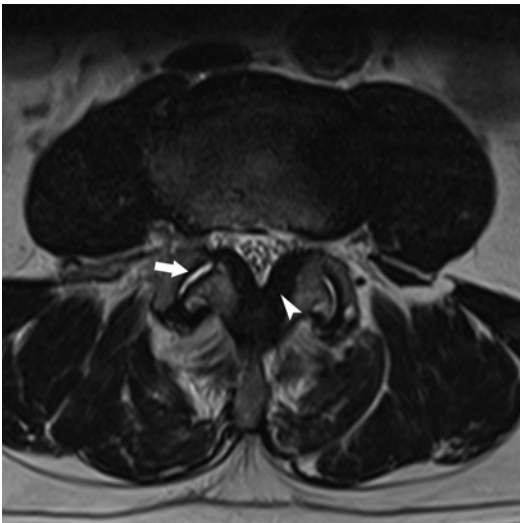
Degenerative changes involving L4-L5 facet joints. Hyperintense signal consistent with facet joint effusion (*arrow*) and hypertrophy of ligamentum flavum (*arrowhead*) are seen on axial T2w MR image
